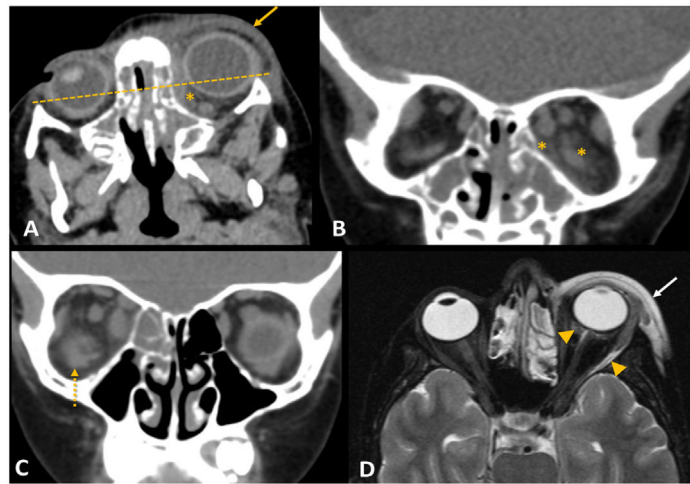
Orbital cellulitis: Axial (A) and coronal (B) non-enhanced CT images, soft tissue window, present opacification of the ethmoid and maxillary sinuses bilaterally, associated to mild proptosis and densification of the left pre- and postseptal fat (arrow and asterisks, respectively), in keeping with preseptal and orbital cellulitis. Note that the orbital fat densification occurs predominantly alongside the lamina papyracea and orbital roof. No fluid collections are seen. (C) Coronal non-enhanced CT images, soft tissue window, of another patient demonstrate opacification of the right ethmoidal cells, associated to postseptal fat-stranding and enlarged ill-defined medial and inferior rectus muscles (white arrow), suggestive of periorbital cellulitis with myositis. (D) Axial fat-saturated T2WI of a different patient shows thickening and hyperintensity of the preseptal fat (white arrow) and high signal intensity in the intraconal and extraconal orbital fat (arrowheads), without discrete collections.
